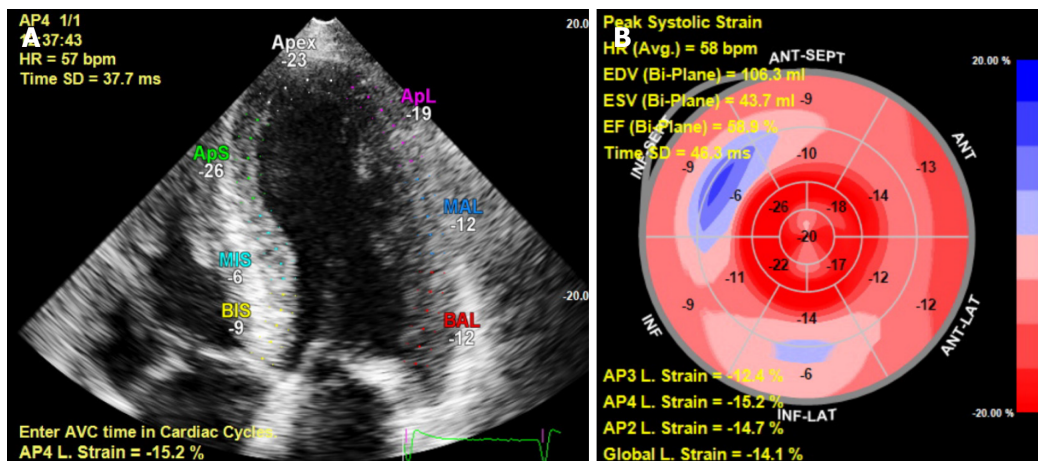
Transthoracic echocardiography imaging from a patient with transthyretin amyloidosis-cardiac amyloidosis. A: Strain imaging by transthoracic echocardiography; B: Reduced mid and basal values with apical sparing.
